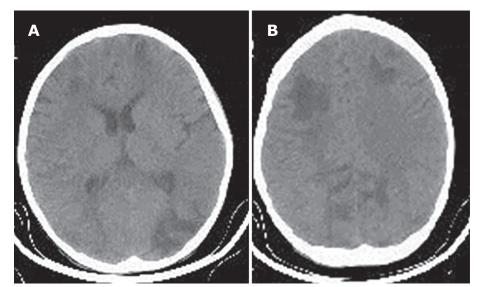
The axial non-contrast brain CT-Scan demonstrating hypodensity involving white and grey matter of bilateral occipital lobes (A) and bilateral frontal lobes (B).
